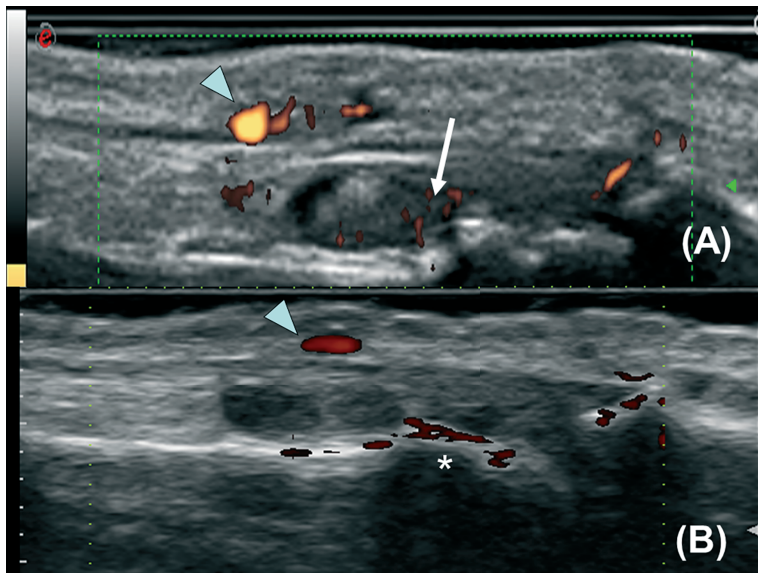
Interphalangeal joint of the first digit of the right hand with two different machines in the same patient. (A) Machine B: presence of positive power Doppler signal (arrow) within the region of synovial proliferation. (B) In the image made with machine A this signal is absent; vessel (arrowhead); Noise on cortical surface (*)
